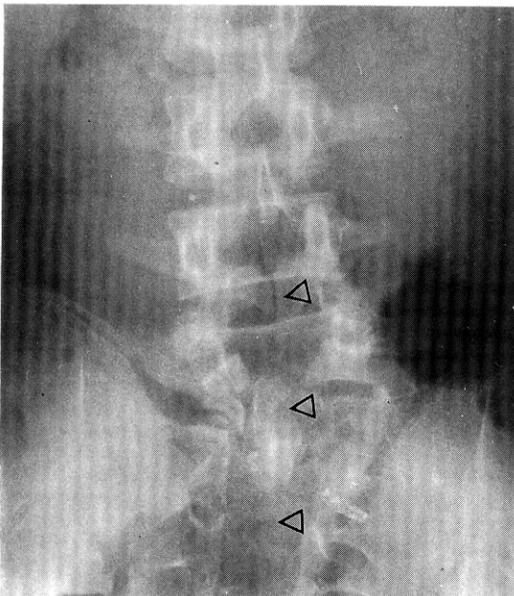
Lumbar radiography shows scoliosis and defective laminae from L-4 to total sacral segments (△).
